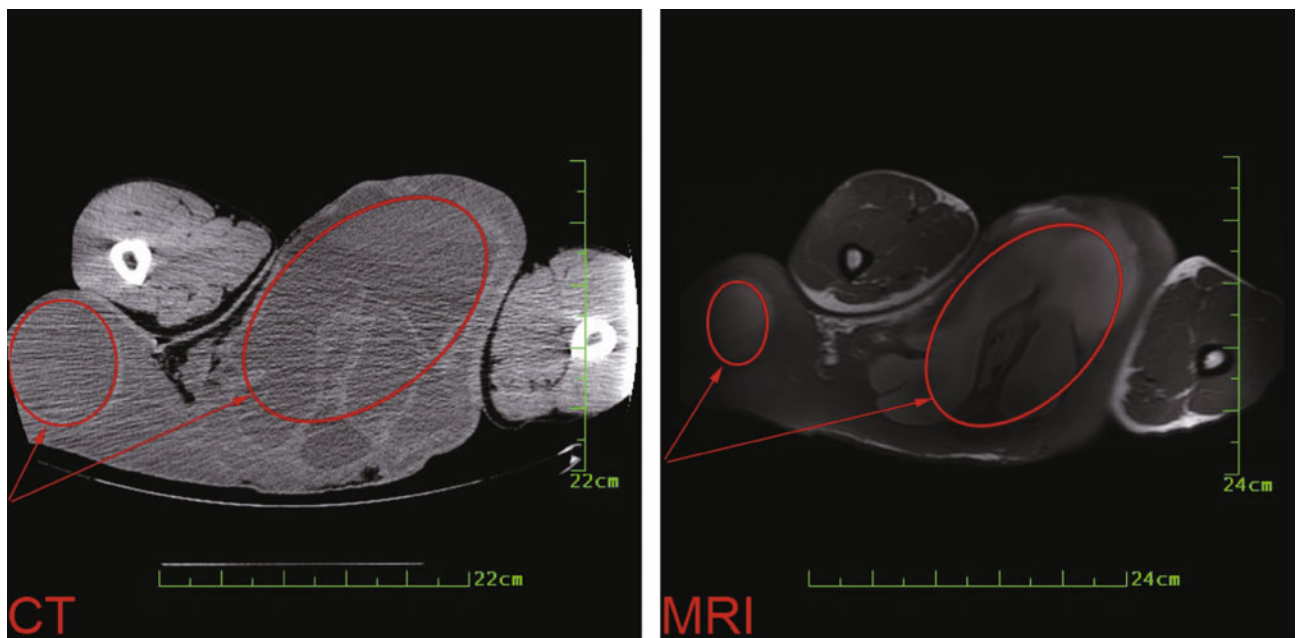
The CT scan and MRI images of the cyst. CT scan and MRI suggested a huge cystic mass in perineum and pelvic, which was exactly a multilocular cystic mass, and the thickness of cystic walls were uneven.
